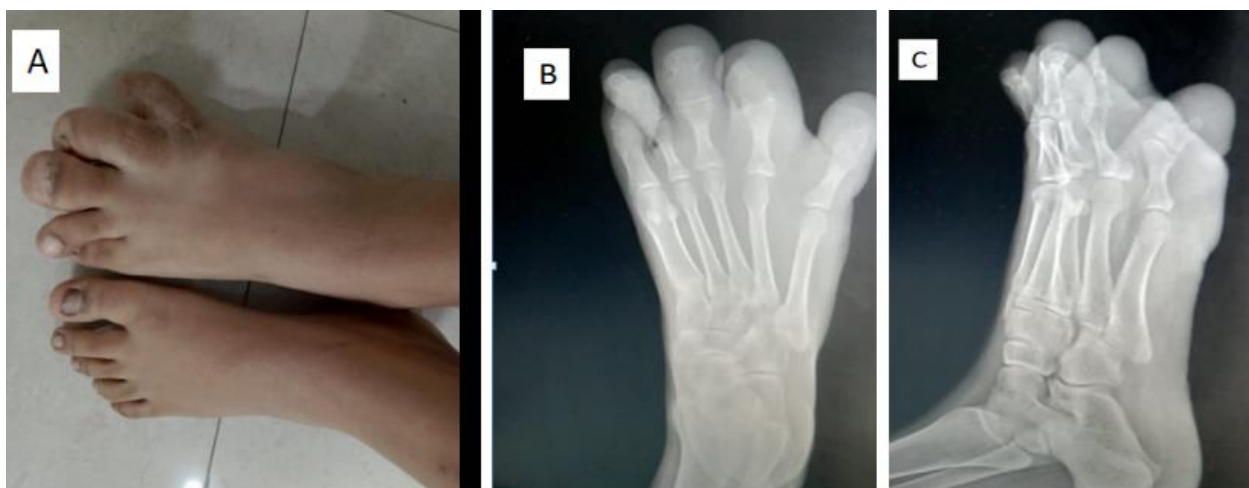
(A) Clinically, the patient presented with diffuse enlargement of the third, fourth, and fifth toes. (B) & (C) AP & lateral radiograph shows osseous hypertrophy of phalanges of the 3rd, 4th and 5th toes
